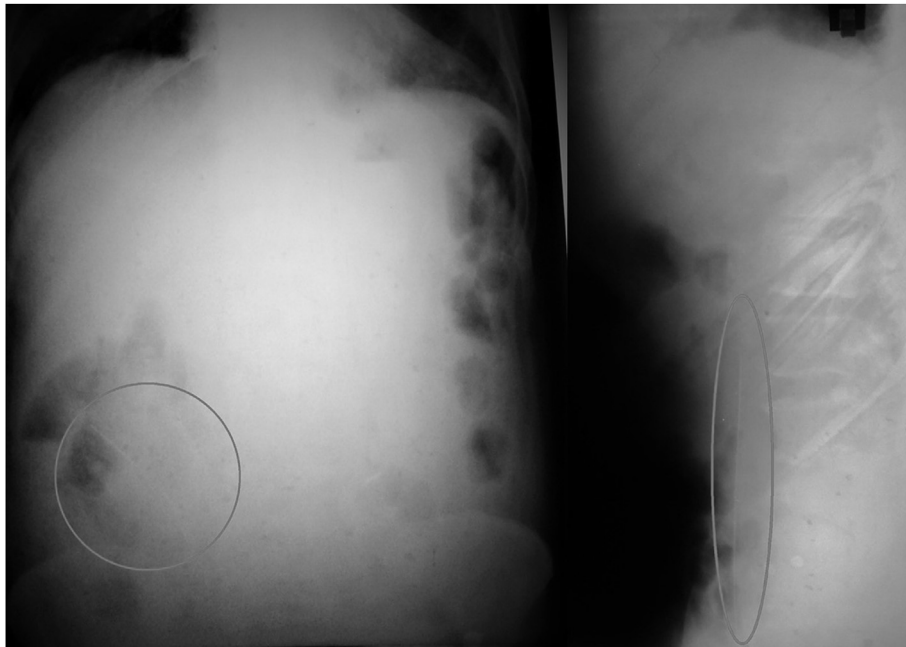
X-ray erect abdomen antero-posterior and lateral views showing a linear radio-opaque density suggestive of migrated drain in the peritoneal cavity.
